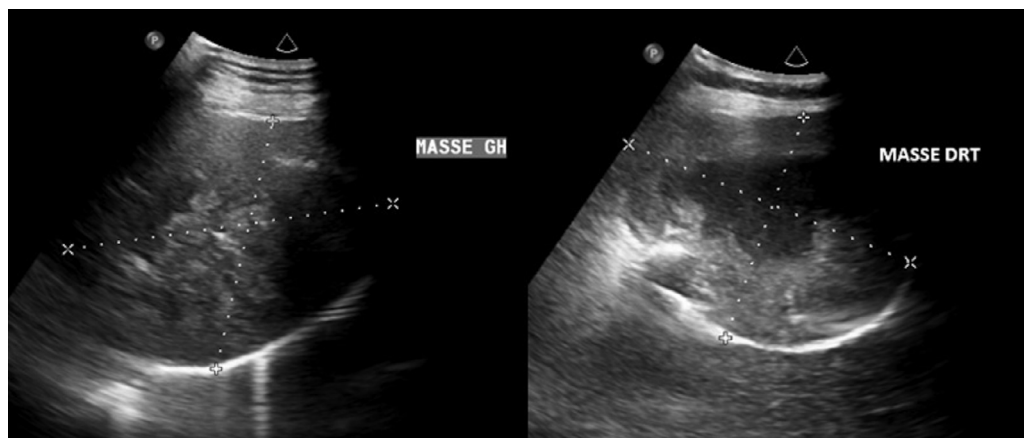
Ultrasound image before biopsy: heterogeneous tissue masses with hypo echoic central areas and calcifications.
